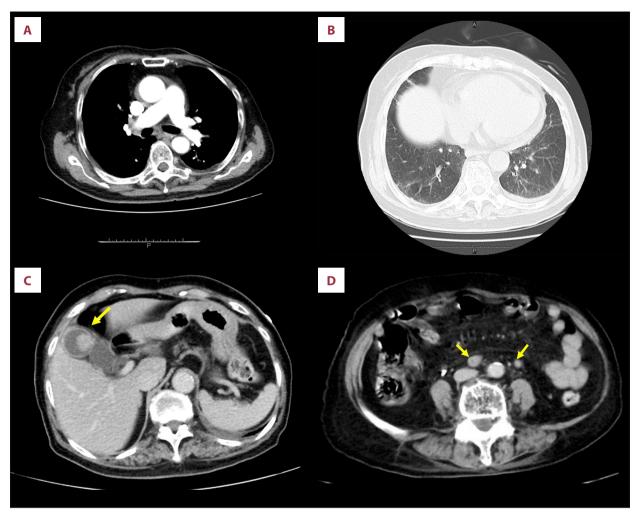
(A) Enhanced chest CT findings. (B) Plain chest CT findings (pulmonary window setting). (C) Enhanced abdominal CT findings. The yellow arrow indicates advanced gallbladder carcinoma. (D) Enhanced abdominal CT findings. The yellow arrow indicates carcinomatous peritonitis.
